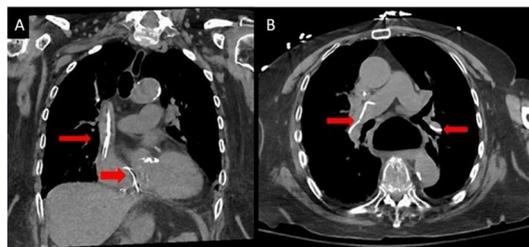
(A; arrows) Non-contrast coronal chest CT showing cement emboli in superior vena cava, right atrium and right ventricle. (B; arrows) Non-contrast axial chest CT showing cement emboli in right and left pulmonary arteries.
